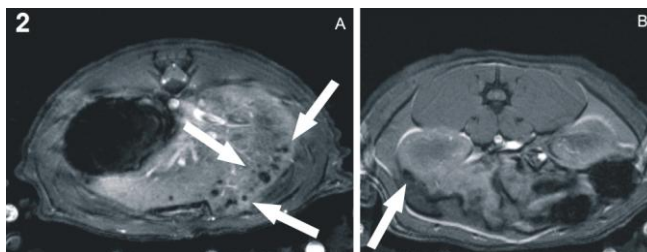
MRI of labeled islets transplanted A) into the liver and B) beneath the kidney capsule.
